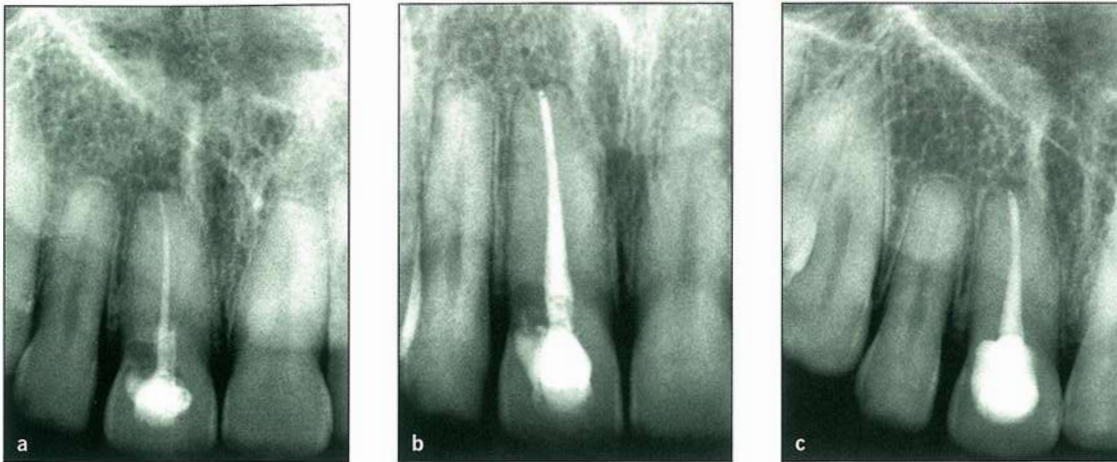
(a) Preoperative radiograph of a central incisor with coronal root resorption and inadequate root canal treatment. (b) Radiograph after retreatment. (c) Postoperative radiograph after repair of the perforation with Geristore.
